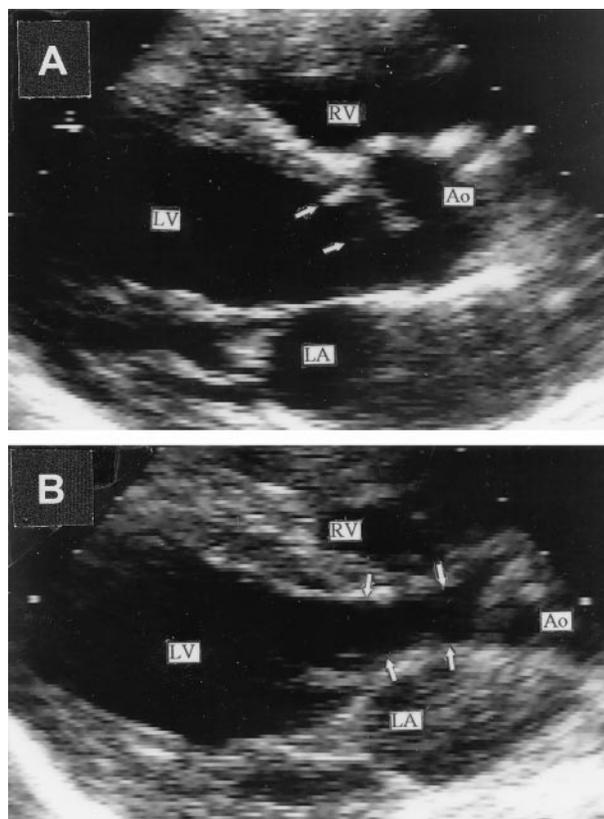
Cross-sectional parasternal long-axis echocardiographic views. A, Discrete subaortic ledge in an 8-year old boy with no significant gradient across the lesion. The ledge is seen beneath the right coronary aortic cusp (arrows). After early operation, preoperative symptoms of "asthma" disappeared. B, Long-segment fibromuscular tunnel-type lesion (arrows) in a 7-year old girl with effort-induced chest pain and a calculated peak LVOT gradient of 90 mm Hg. Resection and extensive septal myomectomy resulted in elimination of the obstruction. Ao = aorta; LA = left atrium. LV = left ventricle; RV = right ventricle.
